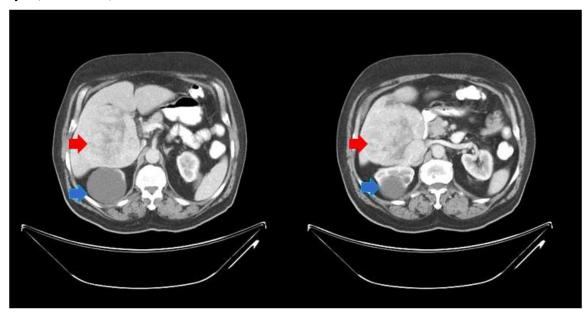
CT- Scan image showing a hepatocellular carcinoma (red arrows) & right renal cortical cyst (blue arrows).
